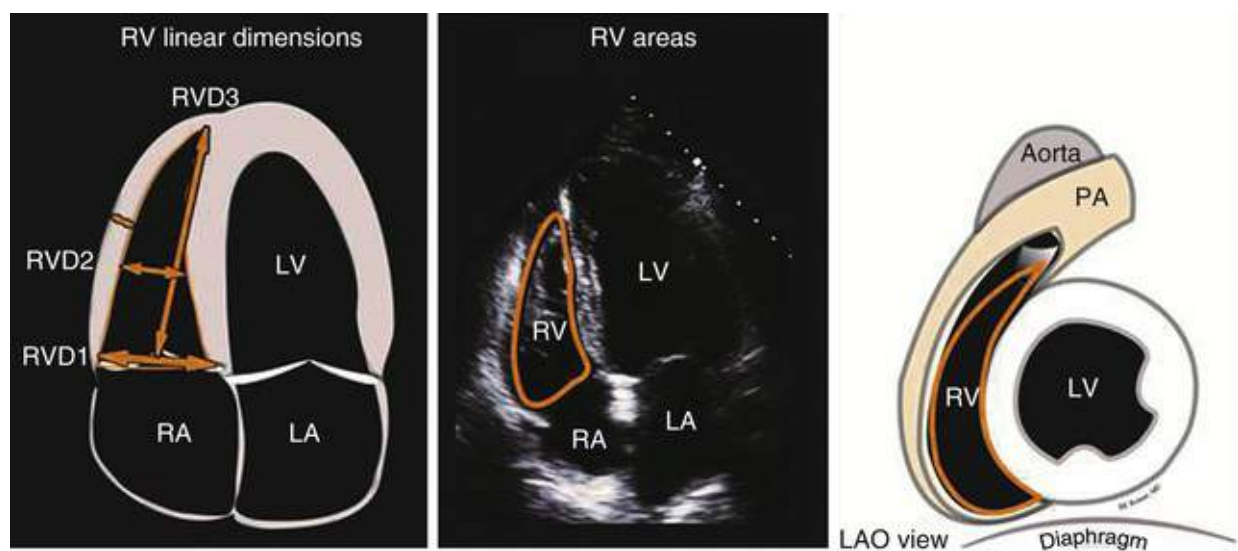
Right ventricular linear and area measurements on 2D echocardiography. The right ventricle is a tripartite shape, with a half-crescent shape in long-axis windows and a crescentic cross section in short-axis views. As a rough guide, from RV-focused apical views (which display the largest basal RV diameter but still center the LV apex at the top of the scanning sector) an RV basal diameter >41 mm and midlevel diameter >35 mm is indicative of RV enlargement (see Table 14.5). LA, Left atrium; LV, left ventricle; PA, pulmonary artery; RA, right atrium; RV, right ventricle. (Modified from Bulwer BE, Solomon SD.
